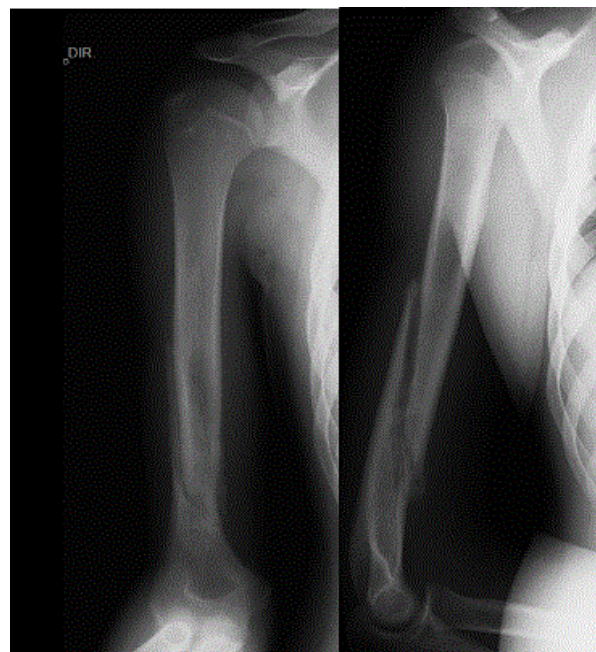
X-ray performed after 6 weeks of cast immobilization, during follow-up.
